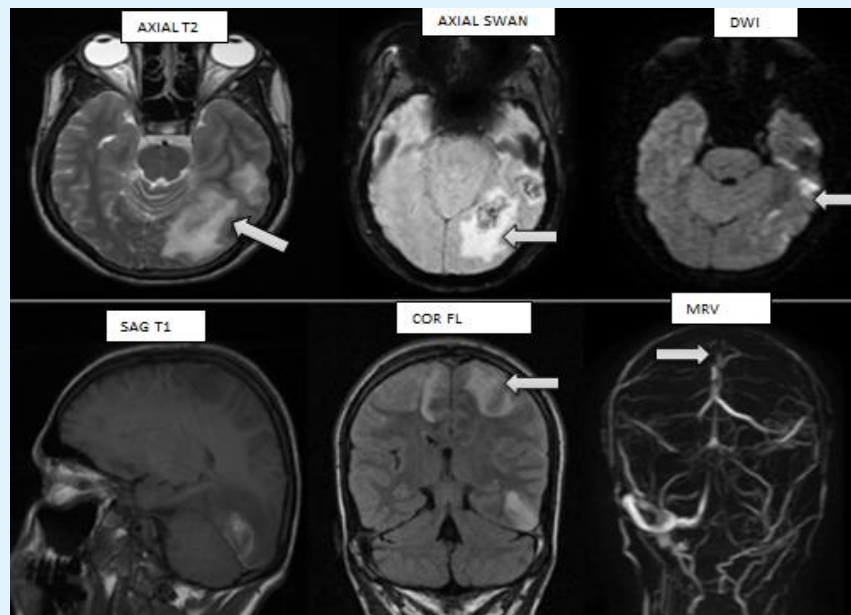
24 year old lady with h/o head ache on post-partum 17th day, Axial T2, SWAN, DWI, Sag T1, Coronal T2 FLAIR and MR Venography reveals haemorrhagic venous infarct with perilesional edema is seen in the left temporal lobe secondary to CVT. MRV shows intrinsic filling defects in superior sagittal sinus, left transverse, sigmoid sinus, IJV and superficial cortical veins.
